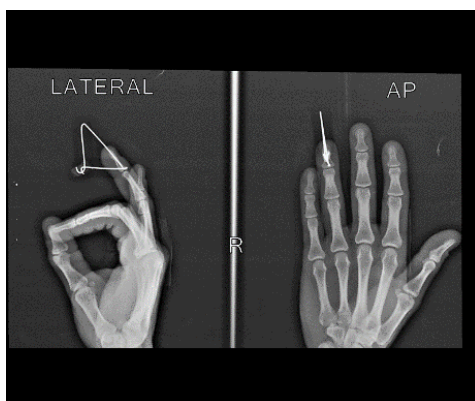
Final radiograph
